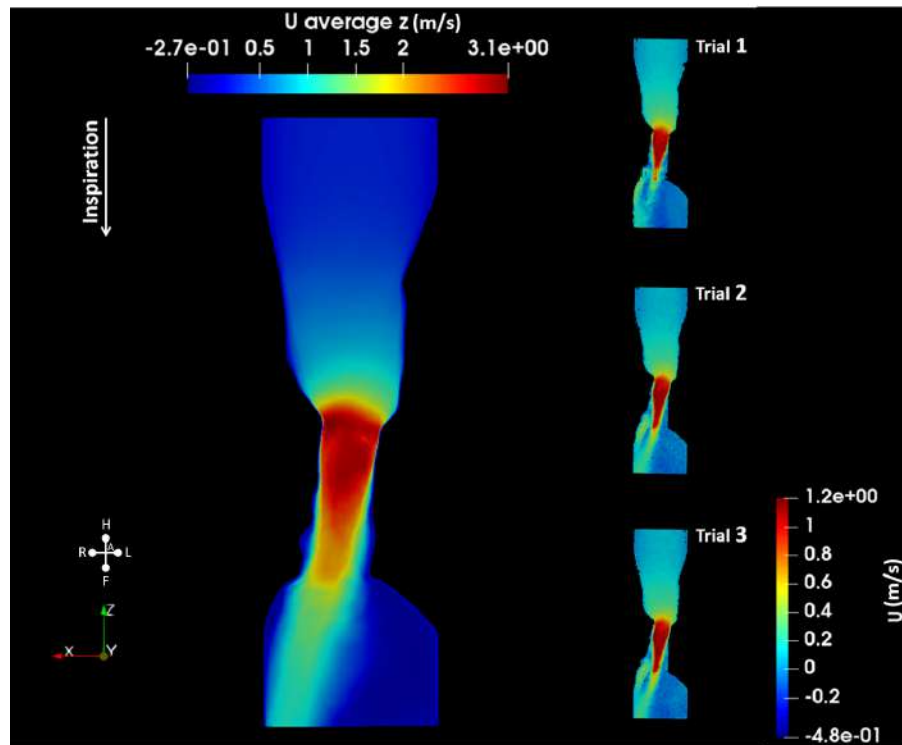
Coronal slice of the CFD and 2D PC-MRI pharynx model showing flow separation during inspiration.
